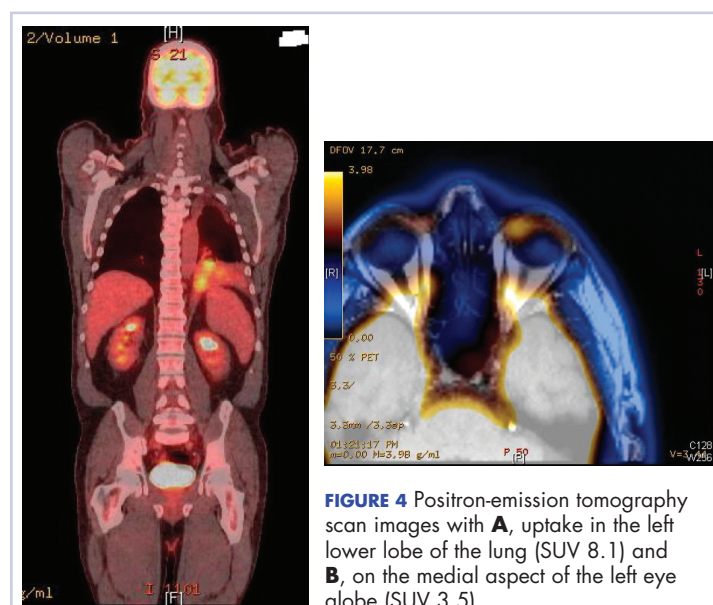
Positron-emission tomography scan images with A, uptake in the left lower lobe of the lung (SUV 8.1) and B, on the medial aspect of the left eye globe (SUV 3.5).
